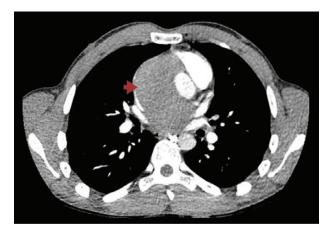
Computed tomography of patient with *Mycobacterium chimaera* infection presenting with aortic dissection with large aortic pseudoaneurysm. *Red arrow indicates false lumen (ie, pseudoaneurysm) of the ascending aorta.
